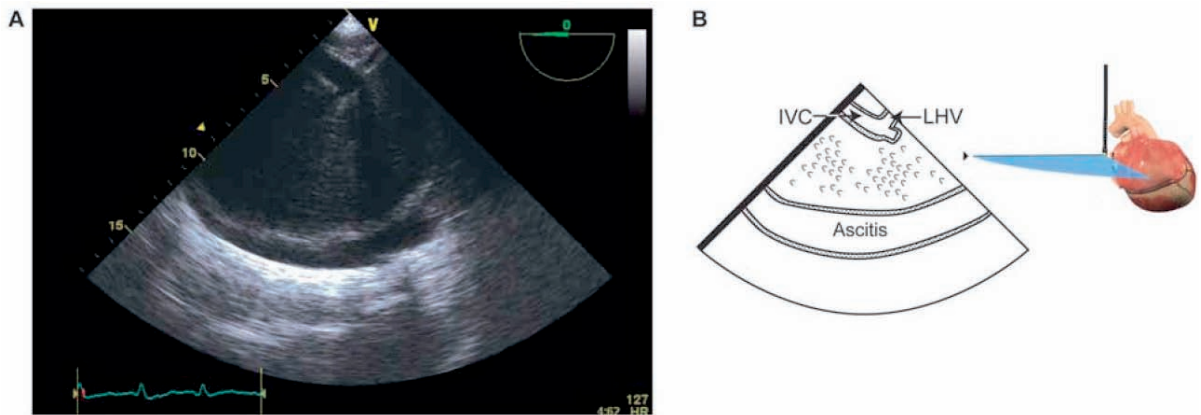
Abdominal examination using transesophageal echocardiography
